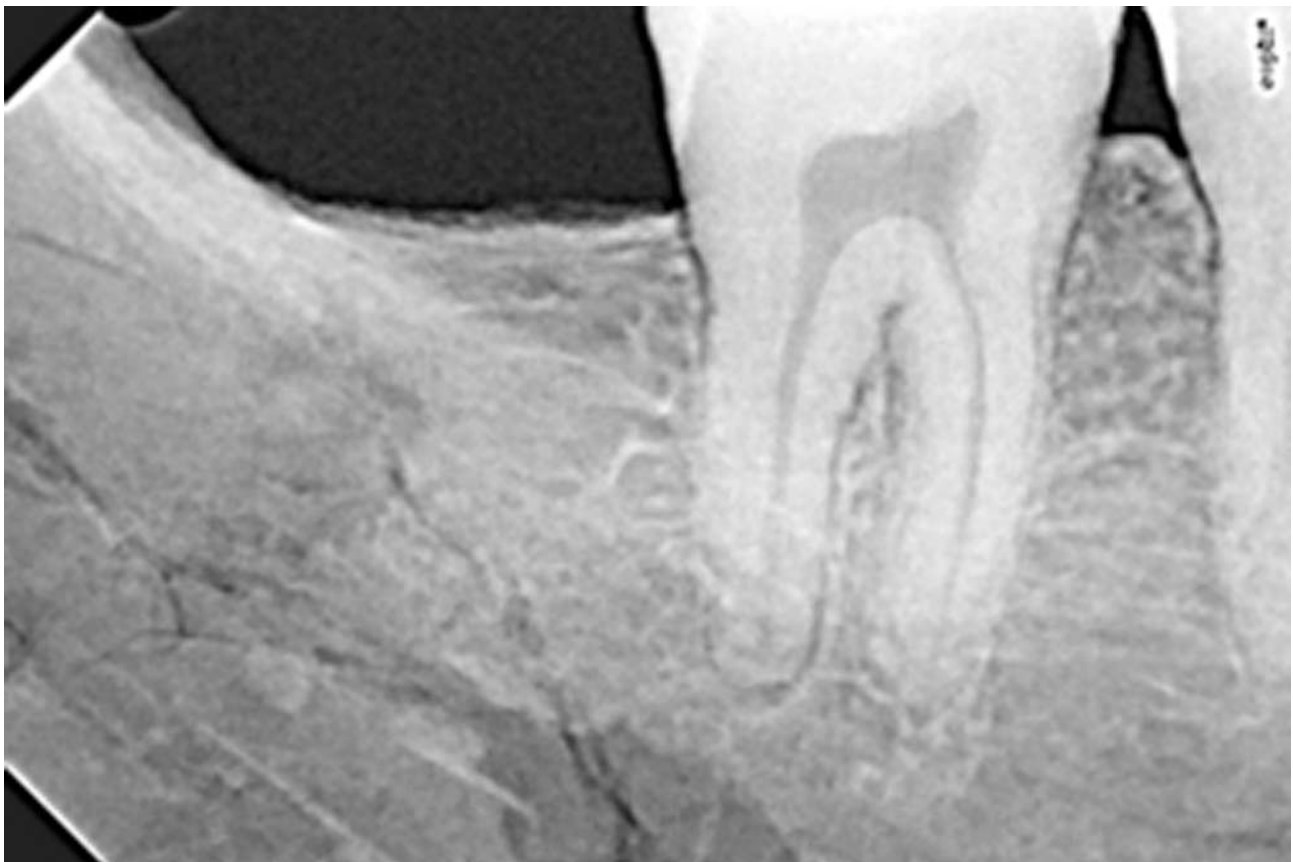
Radiograph of the roots of the left second molar and the third molar agenesis.
